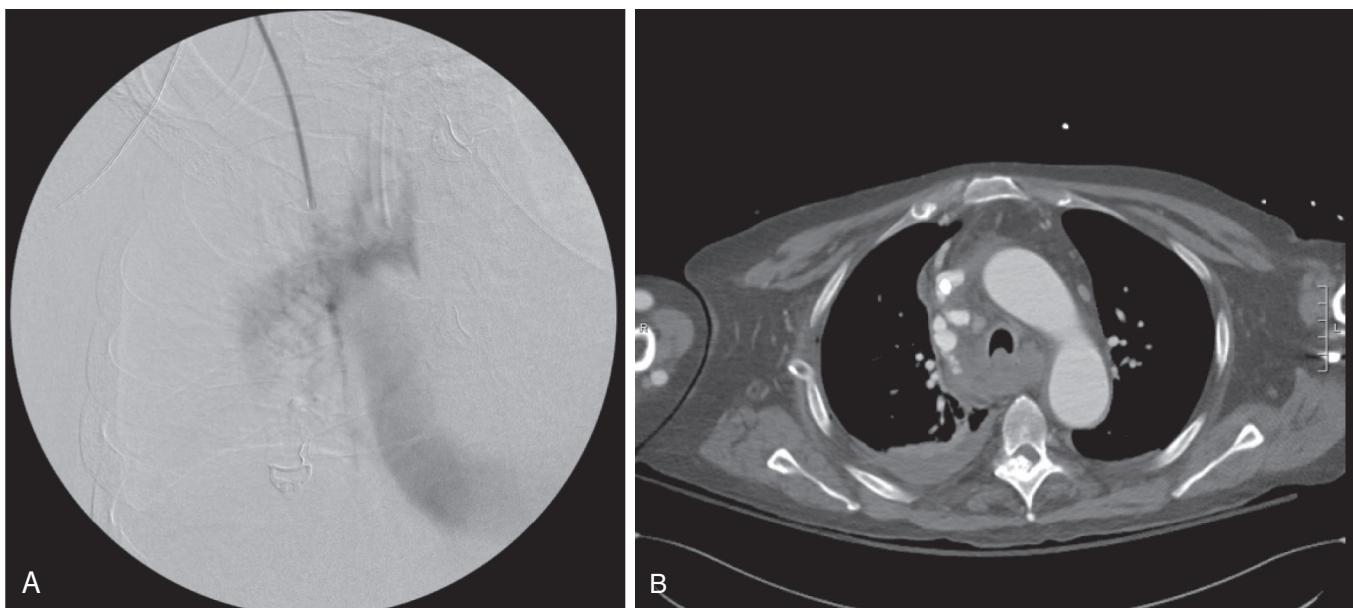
(A) Venogram demonstrating extravasation after attempted recanalization. (B) CT scan demonstrating mediastinal hematoma after attempted recanalization.
